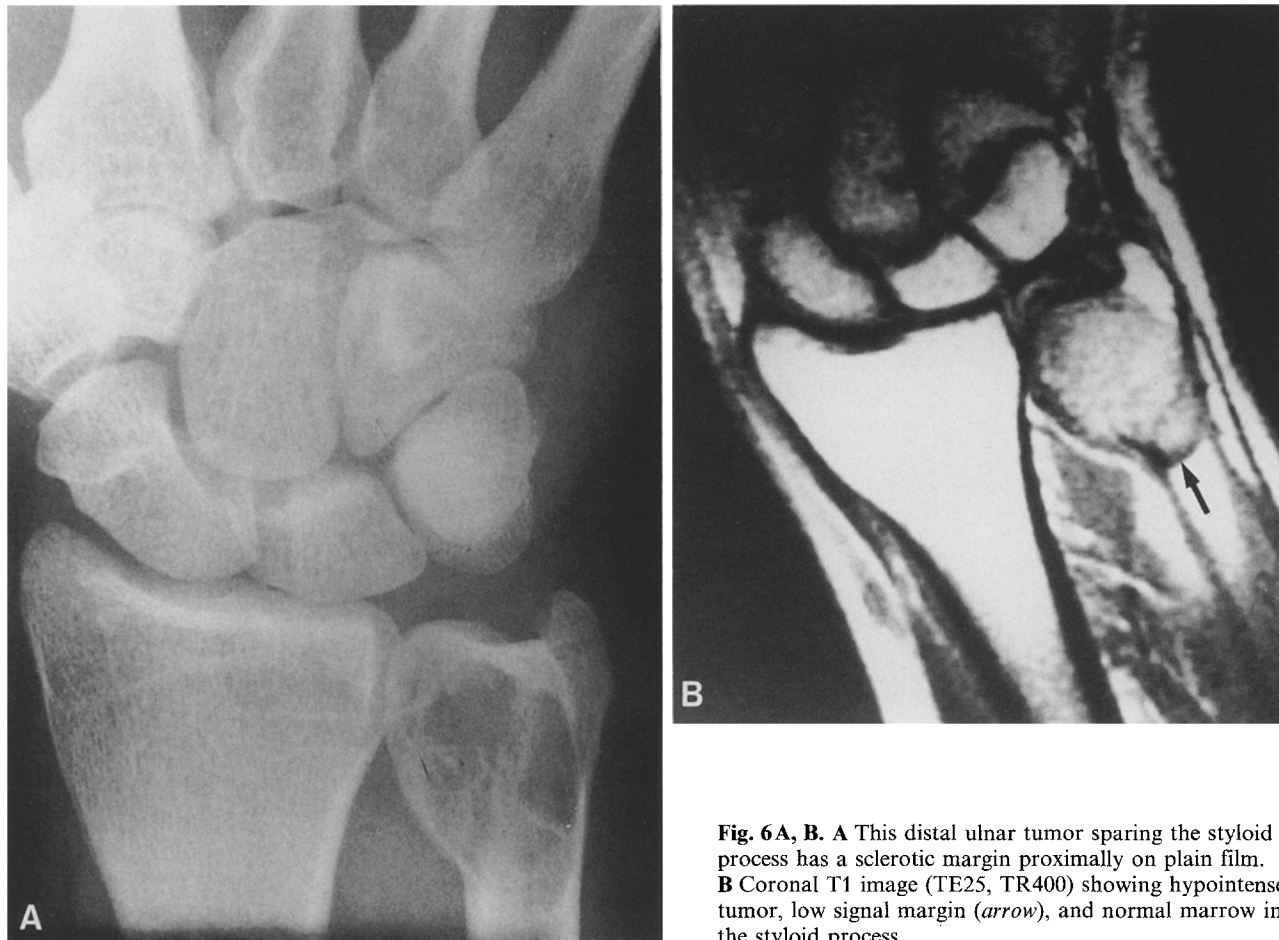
A This distal ulnar tumor sparing the styloid process has a sclerotic margin proximally on plain film. B Coronal T1 image (TE25, TR400) showing hypointense tumor, low signal margin (*arrow*), and normal marrow in the styloid process
